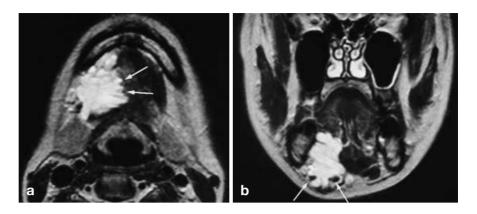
Plunging ranula in a 30-year-old woman. A T2-weighted image reveals a cystic mass in the right submandibular space with slight anterior extension into the sublingual space (*arrows*). This appearance is the "tail sign", characteristic of plunging ranulas
